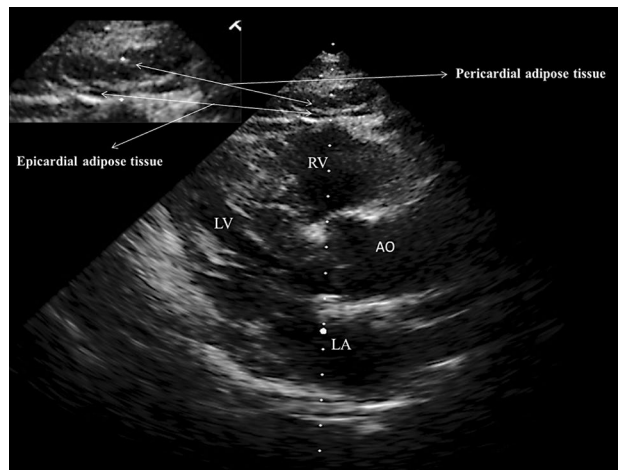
Measurement of epicardial fat thickness by echocardiography. Epicardial adipose tissue, identified as an echo-free space between the outer myocardium and visceral pericardium from the parasternal long-axis view on two-dimensional echocardiography, was measured perpendicularly in front of the right ventricular free wall at end-diastole; AO — aorta; LV — left ventricle; LA — left atrium; RV — right ventricle
